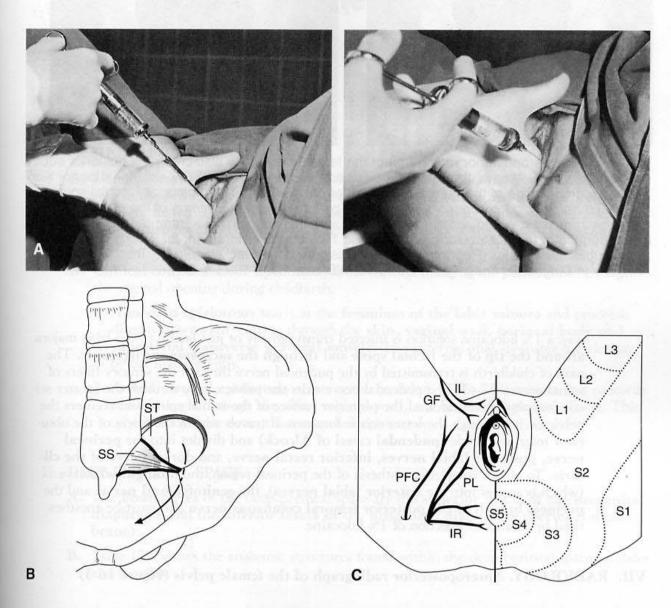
(*A*) Administration of a pudendal nerve block transvaginally and lateral to the labia majora. The ischial spine (not shown) is a good anatomic landmark. (*B*) The path of the pudendal nerve (*curved arrow*) as it passes out of the pelvic cavity through the greater sciatic foramen (posterior to the ischial spine) and returns to the pelvic cavity through the lesser sciatic foramen as it proceeds to the perineum. SS = sacrospinous ligament; ST = sacrotuberous ligament. (*C*) The perineum in the lithotomy position. The posterior labial (*PL*) and inferior rectal (*IR*) nerves are terminal branches of the pudendal nerve. In addition, the ilioinguinal nerve (*IL*), genitofemoral nerve (*GF*), and perineal branch of the posterior femoral cutaneous nerve (*PFC*), which also must be anesthetized by cutaneous injection of 1% lidocaine to obtain complete anesthesia of the perineal region, are shown. Labels L1, L2, L3, S2, S3, S4, and S5 indicate the dermatomes of the perineal region. (*A* reprinted with permission from Scott DB: *Techniques of Regional Anaesthesia*. East Norwalk, CT, Appleton & Lange, 1989, p 159; *B* and *C* adapted from Olson TR: *A.D.A.M. Student Atlas of Anatomy*. Baltimore, Williams & Wilkins, 1996, p 169.
